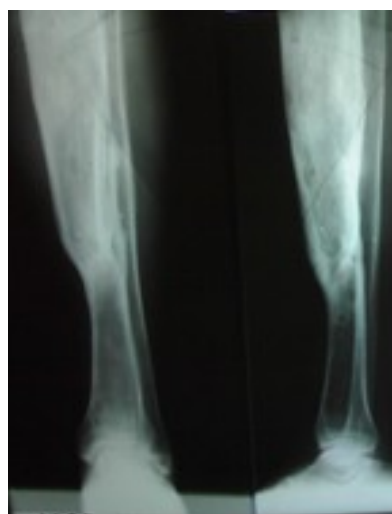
X-Ray in Anterior posterior and Latero-Lateral of Tibia in a patient with healed tibia and chronic osteomyelitis.
